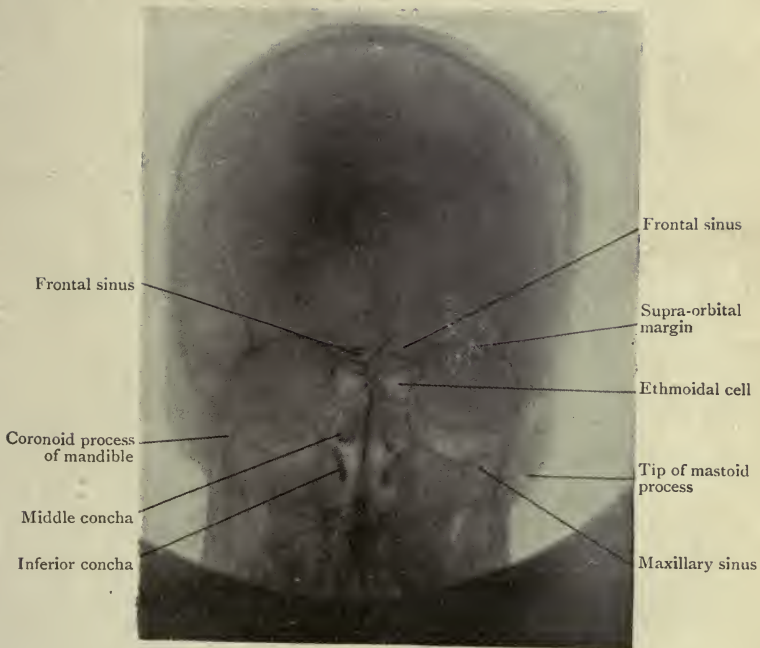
Antero-posterior radiograph of Living Skull. (Gouldesbrough.)
